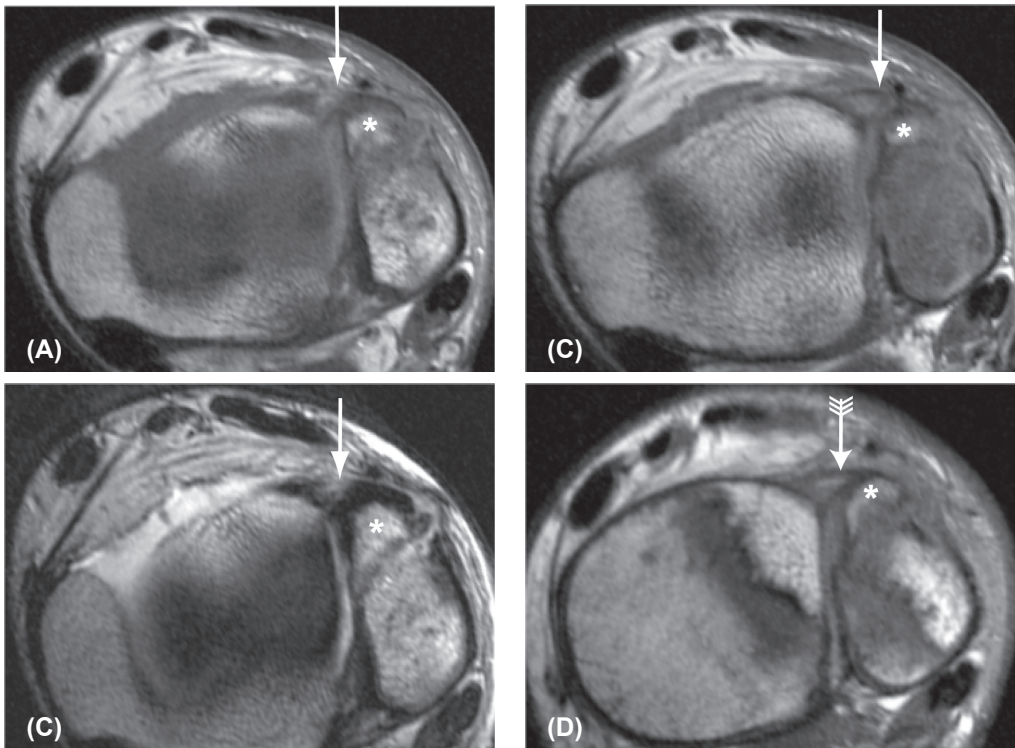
Axial (A, B) and oblique (D) proton density and axial (C) T2-weighted TSE images of a 12-year-old boy. The two axial proton density-weighted images, at two adjacent levels of the distal tibiofibular joint (A, B), demonstrate the avulsion fracture of the anterior aspect of the fibula (Wagstaffe-Lefort, asterisk), with a discontinuous aspect of the anterior distal tibiofibular ligament (arrow). The axial T2-weighted image (C) also shows the fibular avulsion fracture and interrupted anterior syndesmosis. However, on the oblique proton density image (D) the fibular avulsion fragment (asterisk) is attached to an intact anterior distal tibiofibular ligament (arrow).
